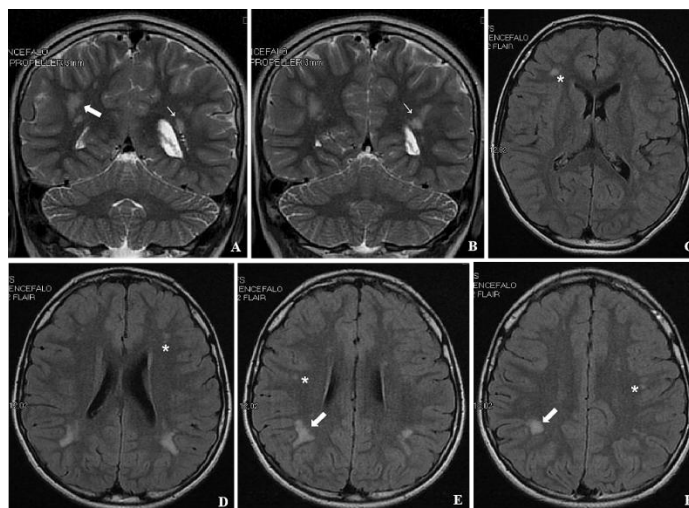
MRI images. Coronal T2 SE. (A and B) Bilateral WM hyperintensities appear large and subcortical on the right (filled arrow) and more peri/paraventricular on the left (thin arrow). The trigone of the left parietal lateral ventricle appears dilated. Axial T1 FLAIR; (C to F) The largest WM hypersignals are almost exclusively in the parietal lobes and are more prevalent on the right side (filled arrows). Many smaller abnormal signals can be seen more anteriorly, but always subcortically (small asterisks).
